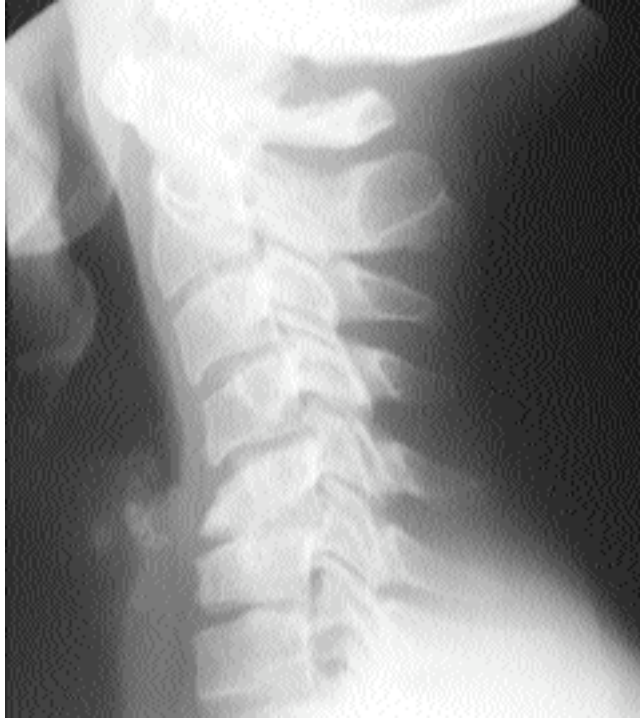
Cervical spine radiograph shows pear-shaped dysplasia of C5, platyspondyly, and kyphosis.
